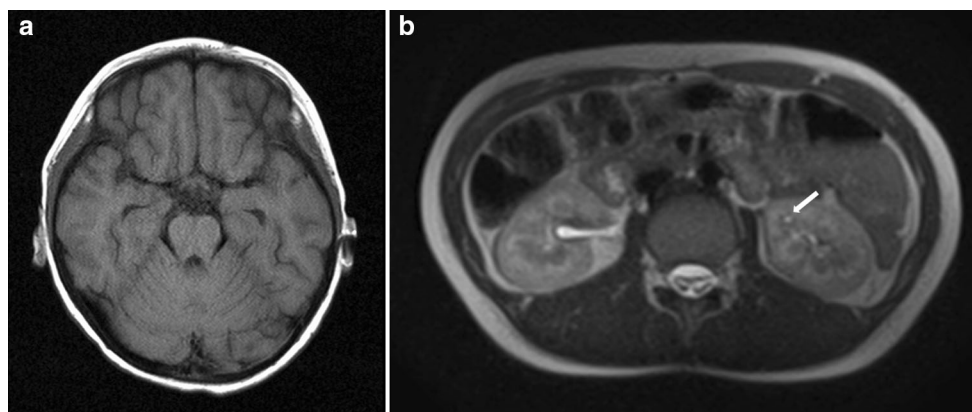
MRI findings of the patients. a Brain MRI of Patient 1. No remarkable changes, including molar tooth sign, were observed. b Abdominal MRI of Patient 3. A small renal cyst was observed in the corticomedullary junction in the left kidney (arrow)
